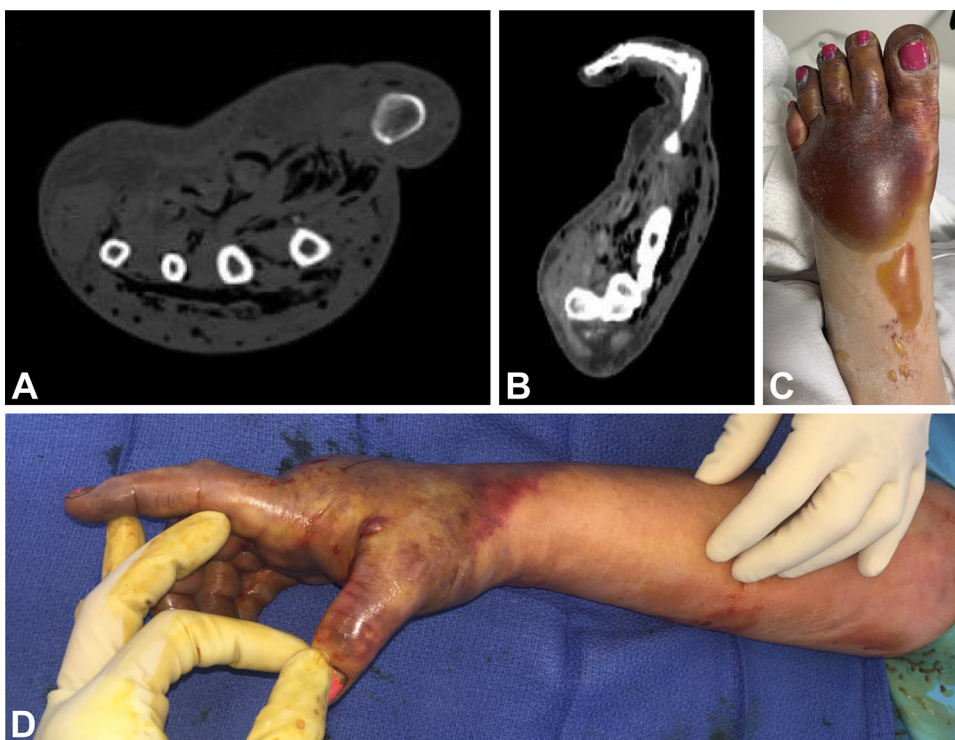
A–B. Computed Tomography Angiogram of Right Upper Extremity upon ED arrival. Imaging showed patent radial, palmar arch, and ulnar artery without stenosis. Extensive subcutaneous, intramuscular, and vascular emphysema along with soft tissue edema was found throughout the hand, suggestive of myonecrosis. Gas was most prominently visualized along the dorsal and ventral aspects of the metacarpals of the (A) wrist and (B) hand. C. Physical exam finding on Day 6. Extensive ecchymosis, bullae, and dusky mottling on extremities. D. Preoperative Photos. Visual characteristics along with imaging were suggestive that below elbow amputation would sufficiently provide margins clear of infection for source control.
